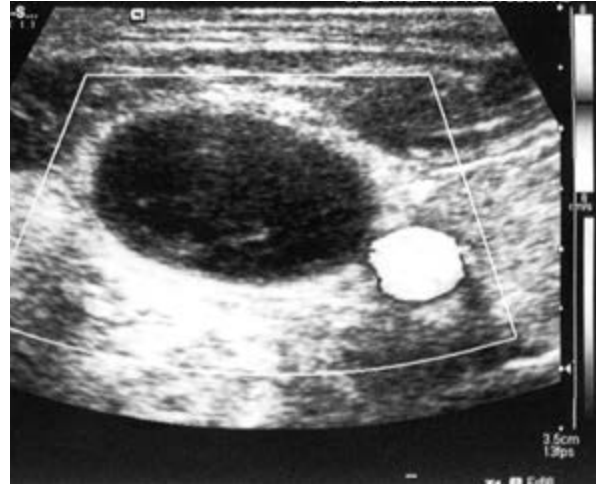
Doppler ultrasound of the left upper extremity and neck revealed extensive thrombosis.
